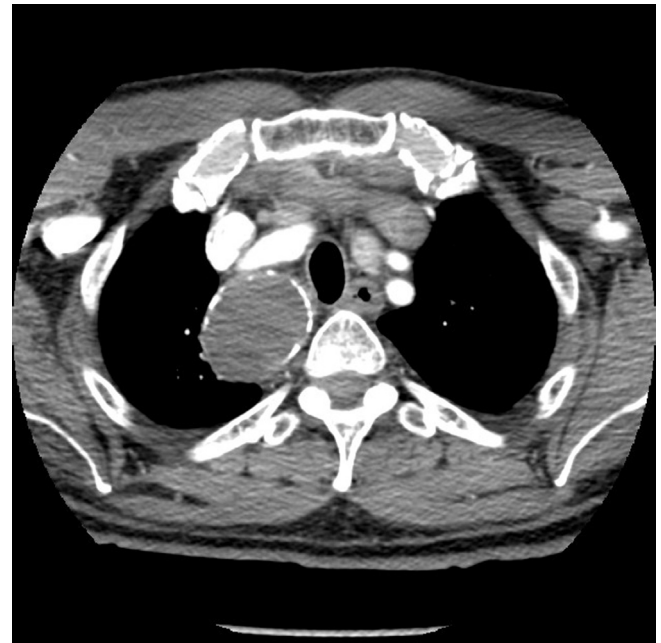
Thoracic sections of the CT scan showing different type of mediastinal goiter and its relationship with surrounding structures.
